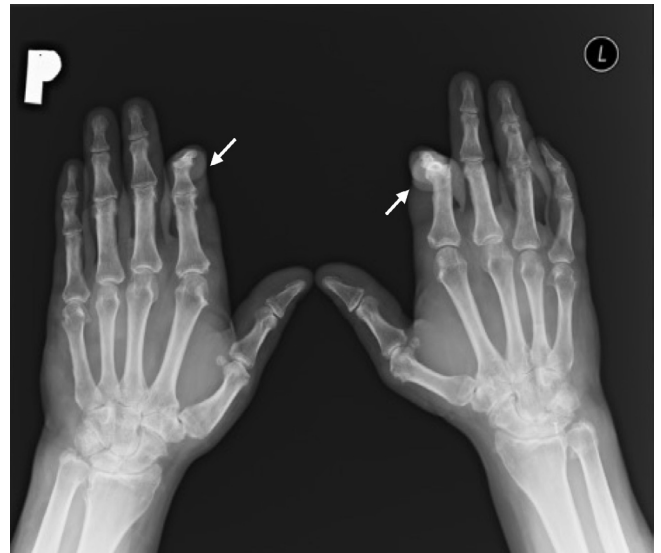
Radiography of hands in pronation, PA projection, year 2019. Thickening of soft tissues and contractures in 2nd PIP joints bilaterally, arrows
